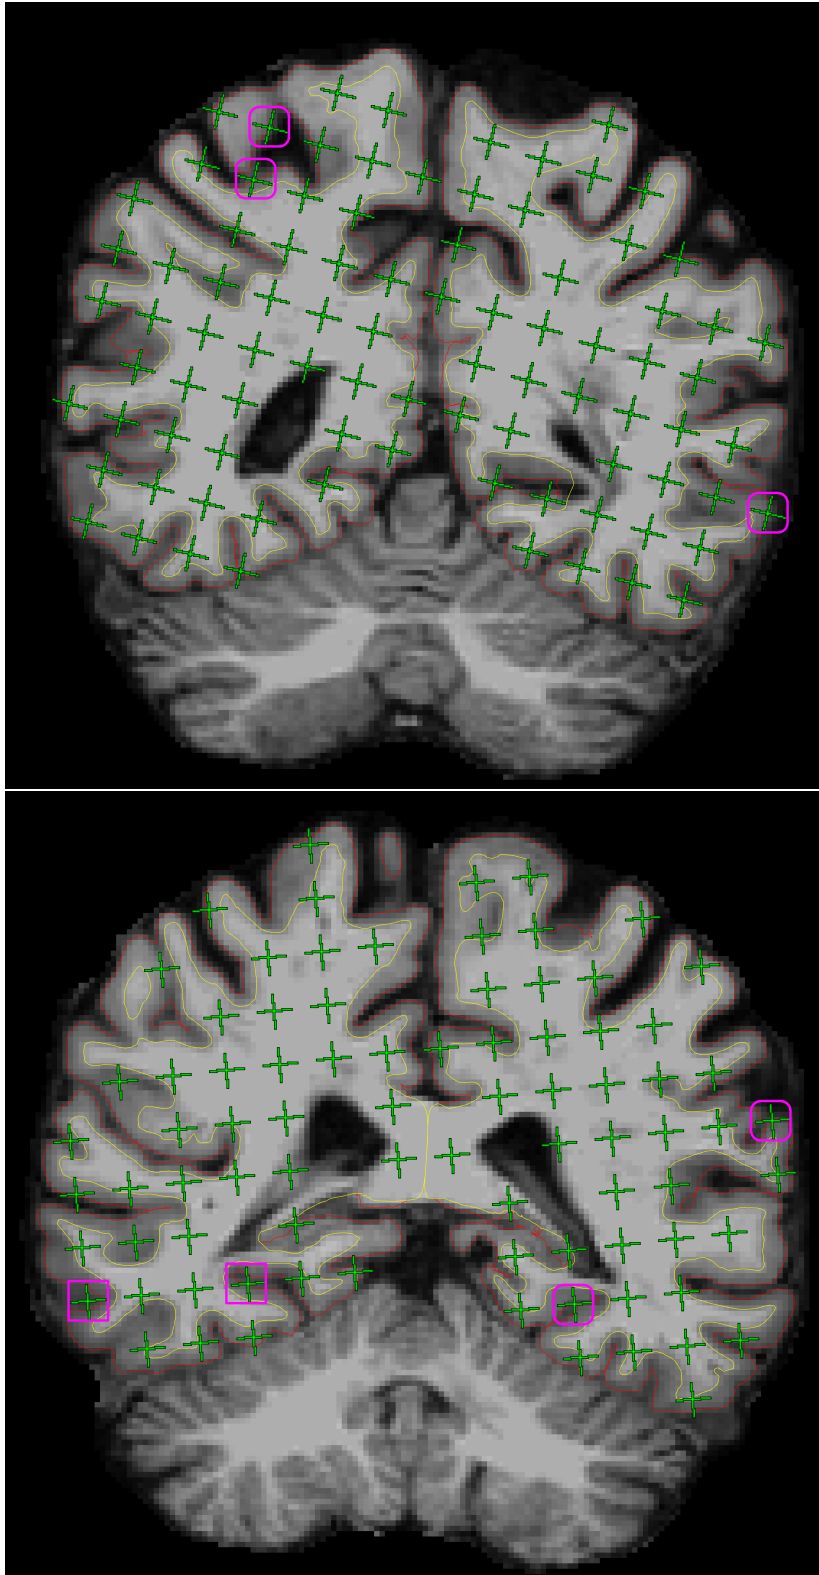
On the 6th and 7th slices of one brain MR image in the coronal view, counted test points (green) hitting the cerebrum (excluding ventricles) are overlaid onto pial profiles (red lines) segmented by FREESURFER. Rectangles (pink) mark the counted test points which fall outside the grey matter boundaries (red lines) and rounded rectangles (pink, racetrack-like) mark the test points hitting exactly on the grey matter boundaries.
